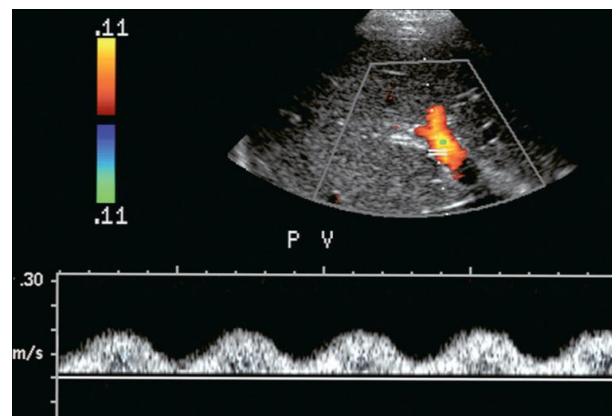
Spectral hepatic vein Doppler tracing in a patient with alcoholic cirrhosis. Portal vein flow profile has become more sinusoidal although the flow direction does remain hepatopetal throughout the cardiac cycle. This degree of periodicity is beyond what we would expect in a normal portal vein. The dip in antegrade velocity coincides with hepatic arterial systole. (Myron A. Pozniak et al 2014)
